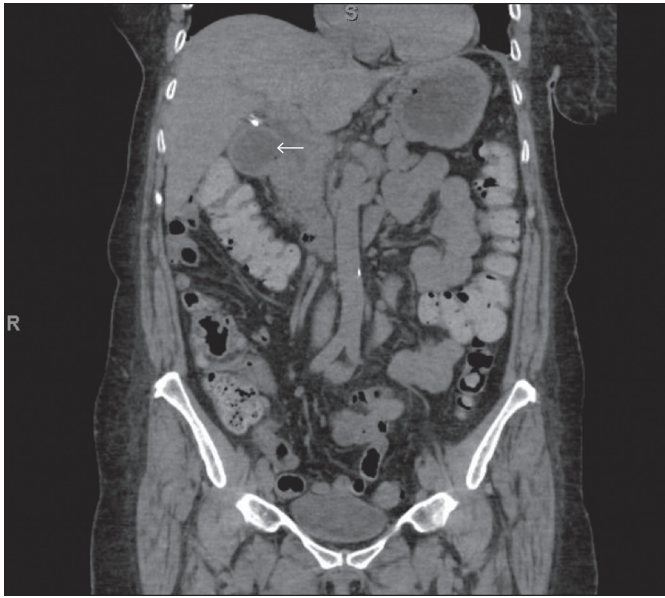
Abdominal CT (coronal view) shows a dilated duodenum and narrowing in the descending duodenum (arrow). There is a 2.2 x 1.6-cm soft tissue postbulbar mass, which is located between the descending duodenum and the pancreatic head, creating the postbulbar obstruction. Fine needle aspiration of the mass at endoscopic ultrasound revealed adenocarcinoma.
